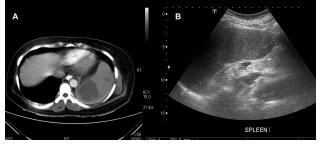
(A) Pretreatment computed tomography scan showing the largest splenic lesion and another lesion superior to it. (B) Ultrasonogram three months after initiation of treatment shows resolution of the lesion.
